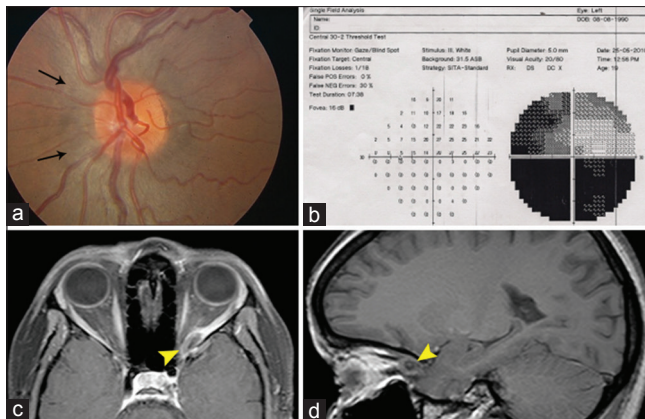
Blurred optic disc margin OS (a) and inferior altitudinal and superotemporal visual field defect (b) with thickening of the posterior part of the laterla rectus on axial MRI (c) and a cyst with scolex on sagittal MRI (d)
